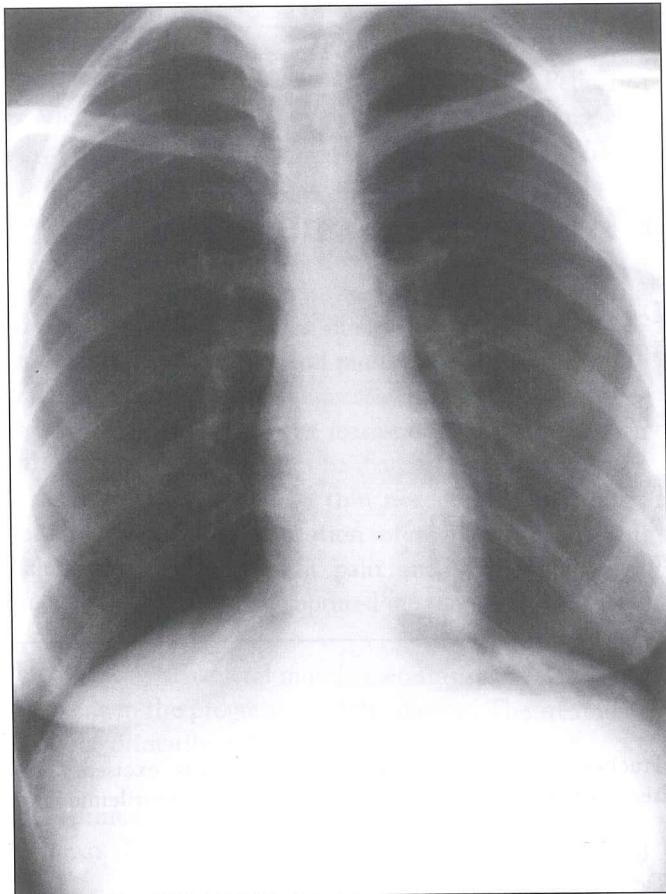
Postero-anterior chest X-ray
